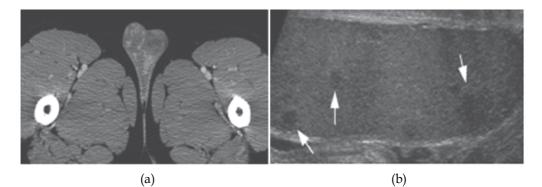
A 30-year-old male with sarcoidosis. (a) Axial contrast-enhanced CT image incidentally shows hypodense lesions within the testes. (b) Subsequent sagittal ultrasonography image of the testes show multiple small round hypoechoic lesions (arrow).
